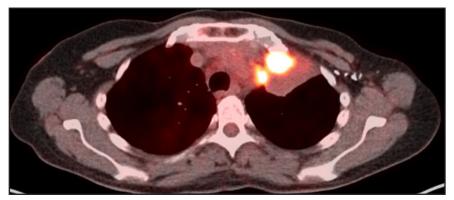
FDG PET/CT image of a 55-year-old female with stage IIIA NSCLC. There is a hypermetabolic lesion in her left upper lobe, max SUV 18.3. The mass is compressing her left bronchus (not shown), resulting in an adjacent soft-tissue density consistent with left upper-lobe collapse. PET nicely differentiates tumor mass from atelectasis.
